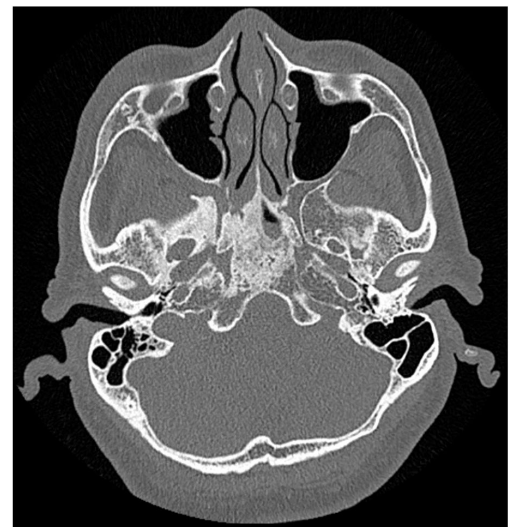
Axial CT of the skull base in bone window showing central skull bases sclerosis and widening of the right foramen ovale, foramen rotundum and pterygopalatine fossa.
